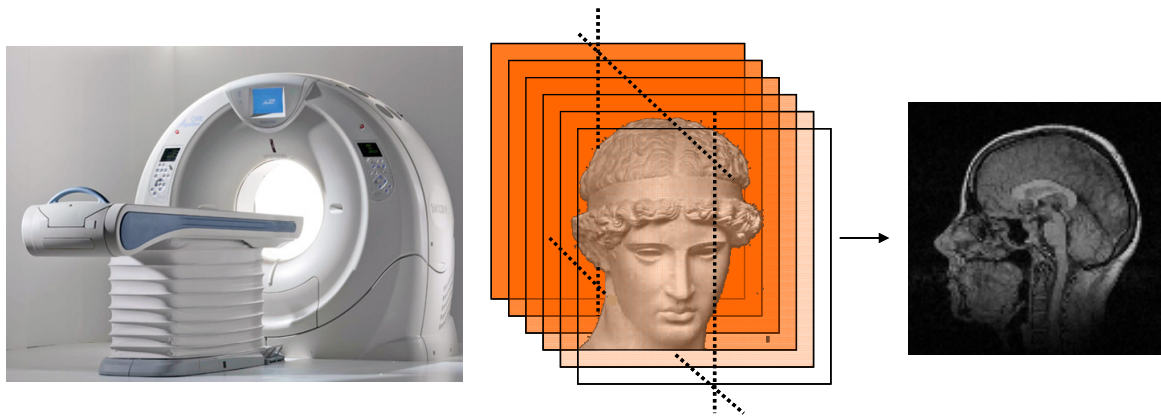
Left) A CT scanner; Right) The authors representation of multiplanar reconstruction.
